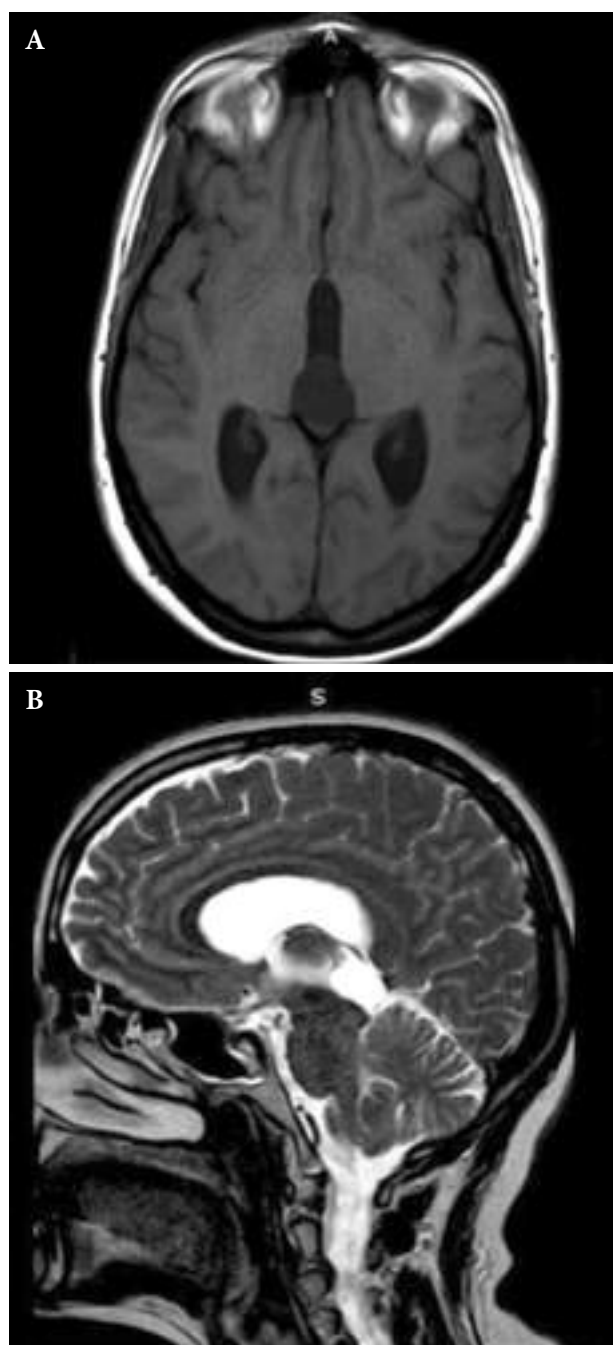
Preoperative MRI images (A: axial T1-weighted; B: sagittal T2-weighted) demonstrating a cystic mass lesion measuring 24 mm in diameter in the pineal region, causing obliteration of the Sylvian aqueduct.
